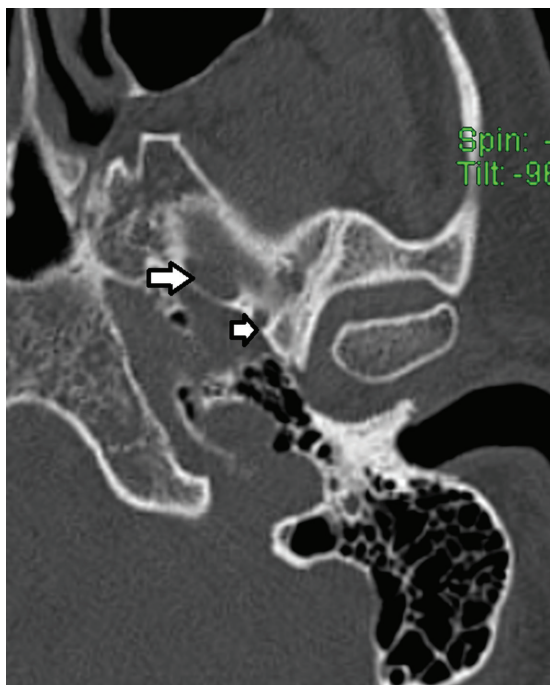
CT, thin slice, bone reconstruction algorithm and window, axial image. Foramen spinosum (small arrow), foramen ovale (large arrow).
